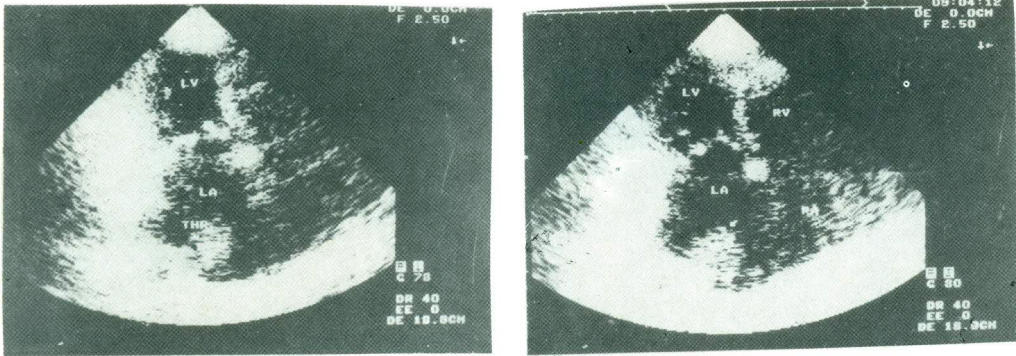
Transesophageal echocardiography four chamber short axis view demonstrating big apical left atrial thrombus. Dilated left atrium with big left atrial thrombus (LAT) attached to its posterior and superior wall.
